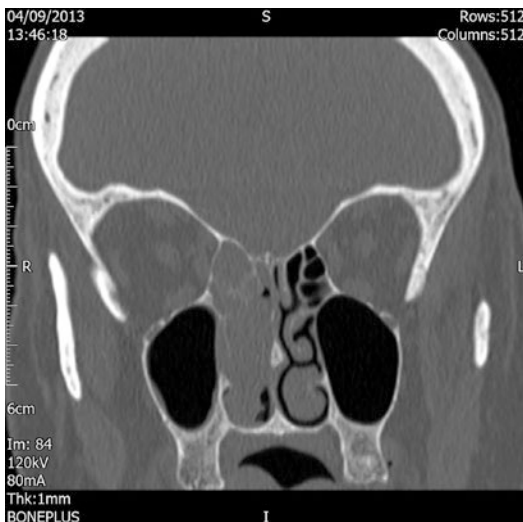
A coronal CT scan of the paranasal sinuses demonstrating involvement of the right posterior ethmoid sinuses and an intact skull base
